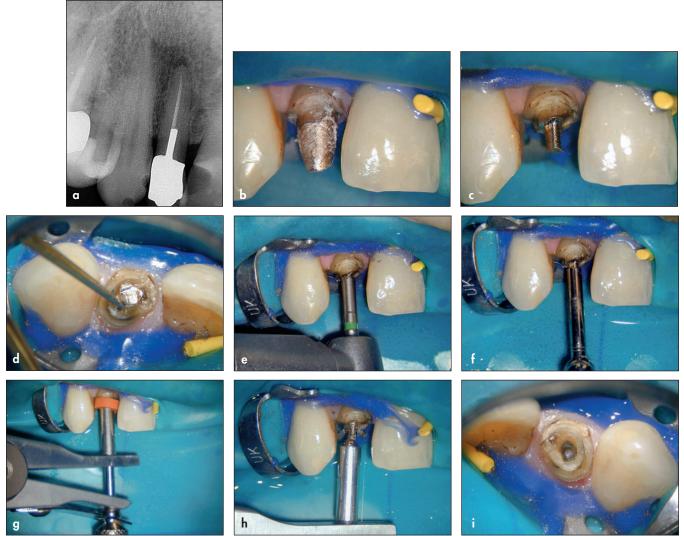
(a) Radiograph of a maxillary right lateral incisor with an apical lesion requiring the removal of a cast post and core and endodontic retreatment. (b) The cast post and core is isolated with rubber dam. (c) The cast post and core is shaped into a roughly cylindric shape. (d) A Munce Discovery Shallow Troughers (CJM Engineering) is used to remove the cement around the post. (e) A special bur is used to thread the head of the cast post and core. (f) Application of counterclockwise rotational force using the wrench. (g) Gonon post in place and ready to be used. (h) The screw is turned to open the jaws and create an extraction force. (i) Removal of post and preservation of the tooth structure. (j) Postoperative radiograph showing the endodontically retreated root canal and the definitive restoration. (Courtesy of Dr Marga Ree, Amsterdam.)
